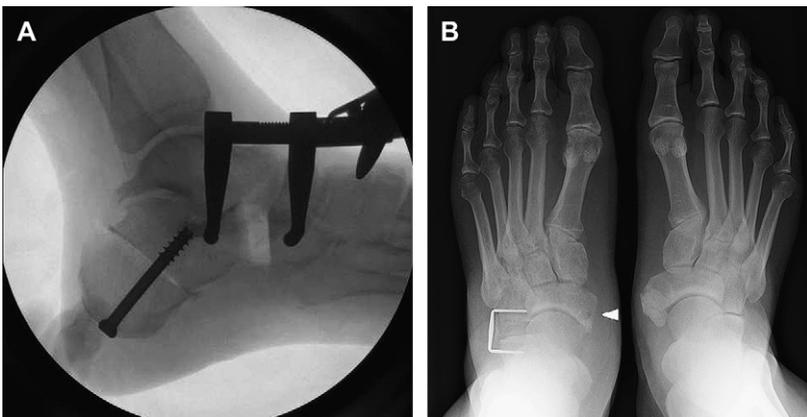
(A) Intraoperative lateral radiograph of the distraction during an LCL procedure. (B) Postoperative anteroposterior radiograph after an FDL transfer, MCO, and LCL. Arrow depicts bone tunnel in the navicular.
